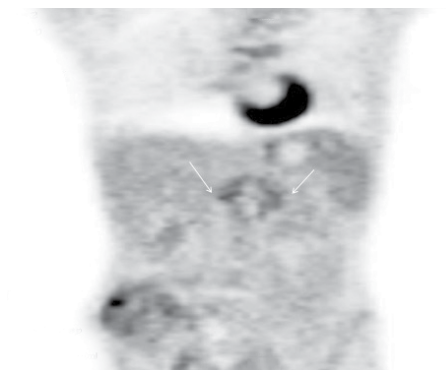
Fluorodeoxyglucose (FDG) positron emission tomography coronal images at the abdominal level show FDG uptake (SUVmax: 1.9) at the thickened wall of the proximal renal arteries
